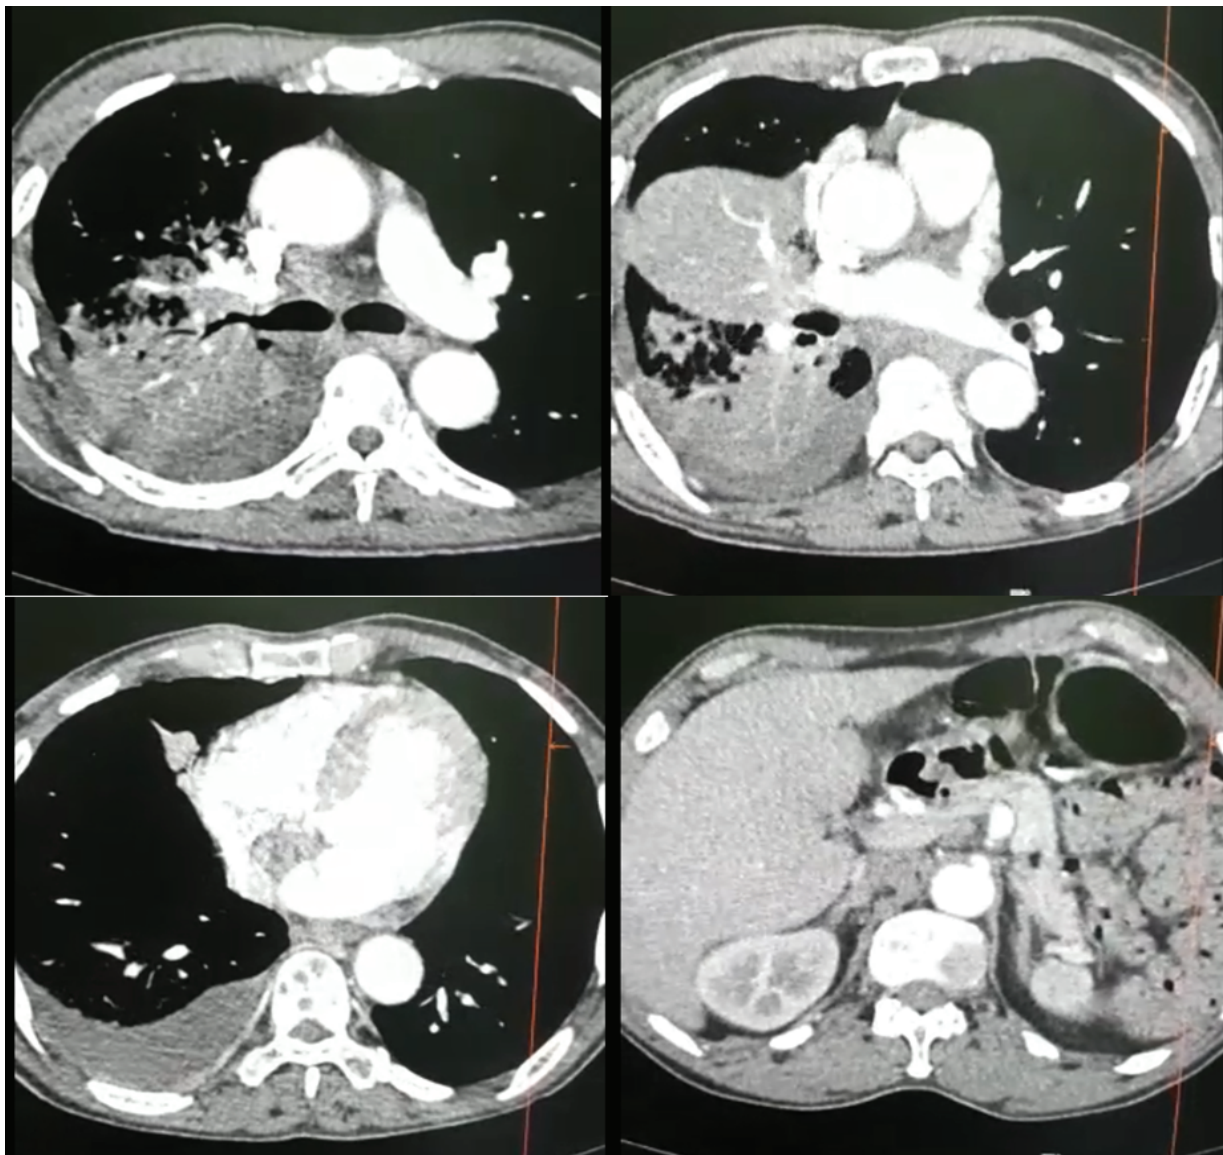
CT 2: Inflammatory consolidation in the middle lobe and lower lobe of the right lung, bone metastasis at the level of the spine and right adrenal gland. Pulmonary inflammatory consolidation is associated with atelectasis and small right pleural effusion and mediastinal lymphadenopathy.
